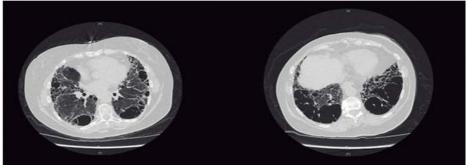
Pulmonary function test results (in A) and high-resolution CT scans of the chest (in B) in a 72-year-old female with "out-of-proportion" dyspnea. Pred: predicted value; Pred LL: lower limit of predicted value; pred UL: upper limit of predicted value; IC: inspiratory capacity; FRCpI: functional residual capacity by plethysmography; ERV: expiratory reserve volume; RV: residual volume; and VA: alveolar volume.
